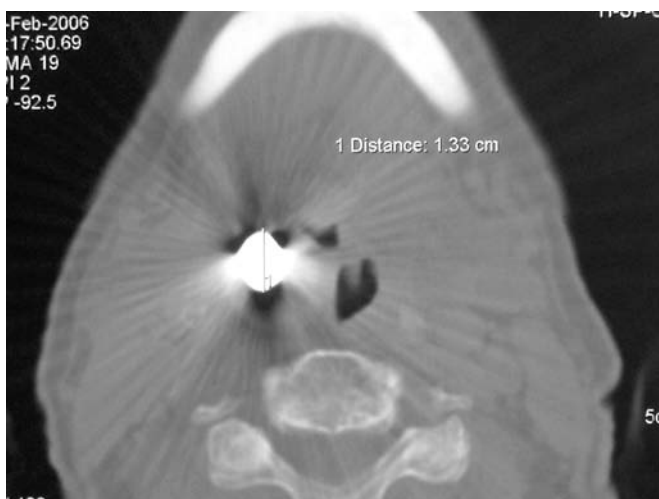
CT scan shows bullet lodged in neck-cross section
